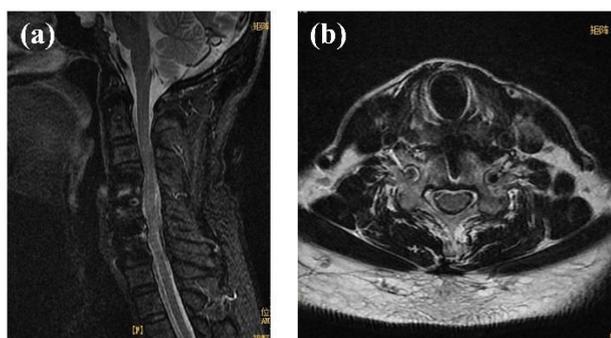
The MRI at 6 months after operation showed that the physiological curvature of cervical spine became straight; Magnetic sensitive artifacts can be seen in C4-7 vertebral body (caused by internal fixation after operation), and no abnormal enhancement is found in cervical vertebral body and paravertebral soft tissue; The morphology and signal of cervical spinal cord are normal, and there is no abnormal enhancement; C1-T1 pre-vertebral and post-vertebral soft tissue edema was basically absorbed.
